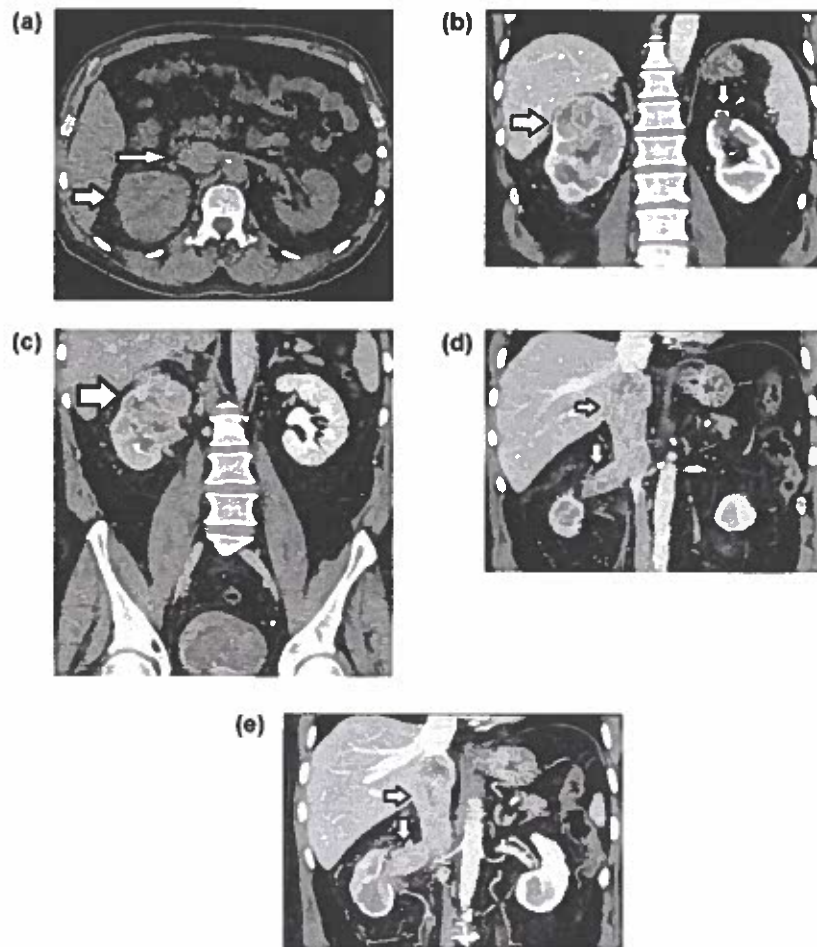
Clear cell RCC with neoplastic involvement of the ipsilateral renal vein and the inferior vena cava (T3b). (a) Axial non-enhanced CT image shows heterogeneous right renal mass (arrow) causing obliteration of the renal sinus. Enlargement of the inferior vena cava (long arrow) is also seen. Coronal reformations during the (b) corticomedullary and (c) the excretory phase depict expanding right renal mass (arrow) heterogeneously enhancing and invading the pelvicalyceal system. A small renal cystic mass with peripheral calcifications (Bosniak classification, version 2019 class II renal cystic mass, small arrow, b) is detected in the upper pole of the left kidney. Coronal (d) multiplanar reformatted and (e) three-dimensional reconstructed maximum-intensity projection, MIP images during the corticomedullary phase show right renal vein and inferior vena cava expanding thrombus, heterogeneously enhancing (arrows). Accurate preoperative evaluation of extent of the neoplastic thrombosis of the inferior vena cava is important for planning the appropriate surgical approach for thrombectomy.
